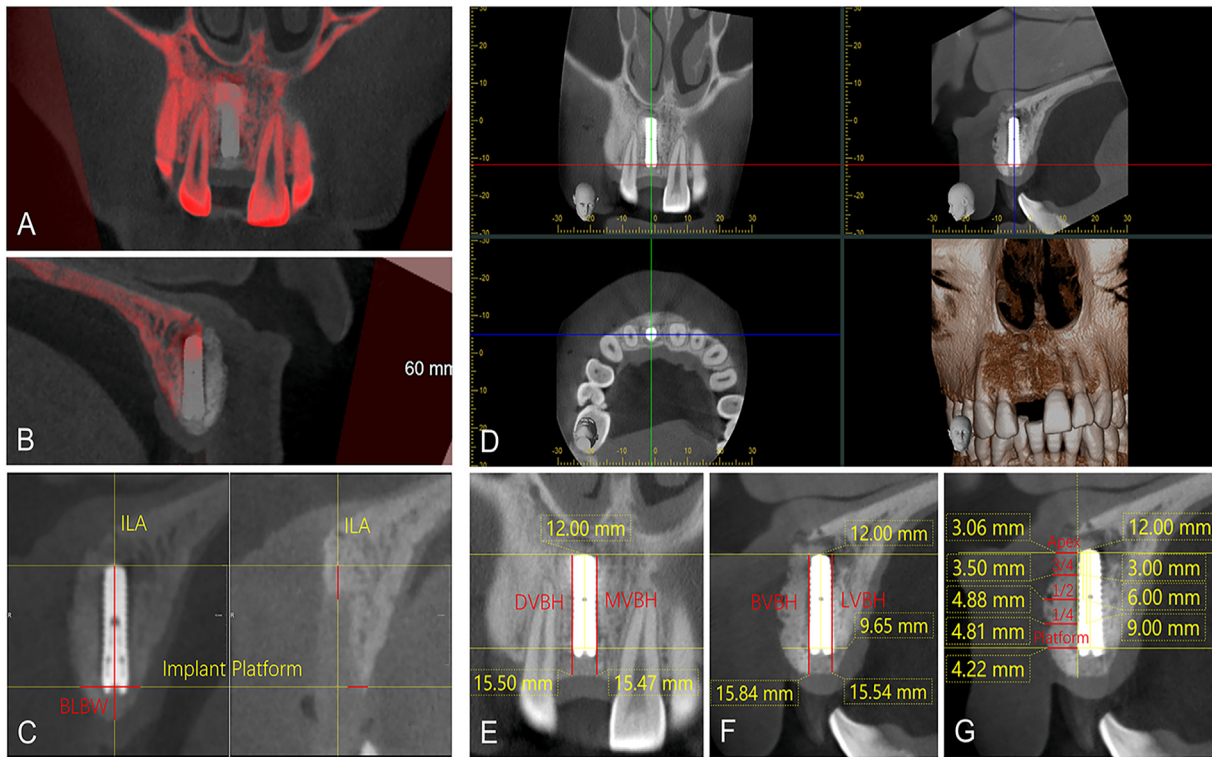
Measurement of the bone around the implant. A&B. CBCT data pre-surgery and 4 months post-surgery overlapped using Mevislab software. C. Vertical bone height and buccolingual horizontal bone width as measured by CBCT. D. Adjustment snapshot of XYZ screen in One Volume Viewer software. E. Measurement of mesial (MVBH) and distal (DVBH) bone height. F. Measurement of buccal (BVBH) and lingual (LVBH) bone height. G. Measurement of implant buccal bone thickness on a different plane. Platform = implant platform, 1/4 = 3 mm apically from the platform of implant, 1/2 = 6 mm apically from the implant platform, 3/4 = 9 mm apically from the implant platform, Apex = apex of the implant. BVBH, buccal vertical bone height; CBCT, cone-beam computed tomography; DVBH, distal vertical bone height; ILA, implant's long axis; LVBH, lingual vertical bone height; MVBH, mesial vertical bone height.
